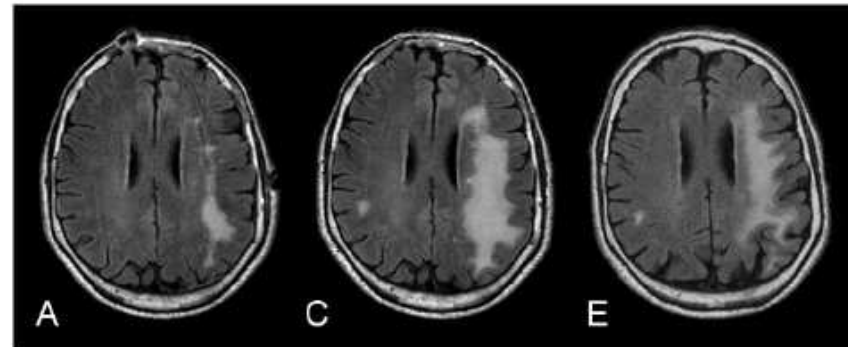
MR imaging at the time of presentation.
